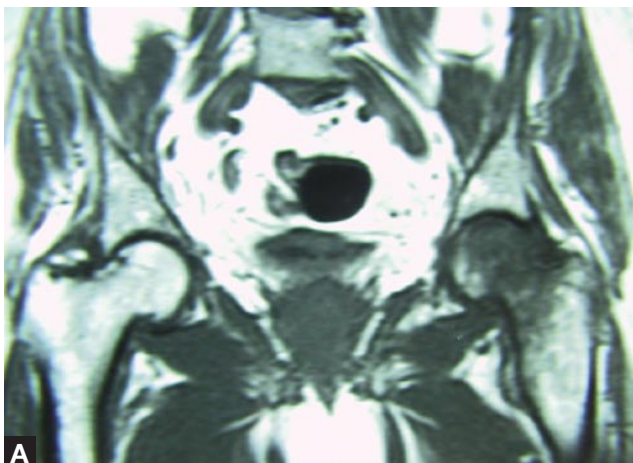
Case 2—(A) T₁-weighted magnetic resonance image of hip shows decreased signal intensity in femoral head and neck suggesting edema. (B) T₂-weighted magnetic resonance image of hip shows increased signal intensity in femoral head and neck suggesting edema.
